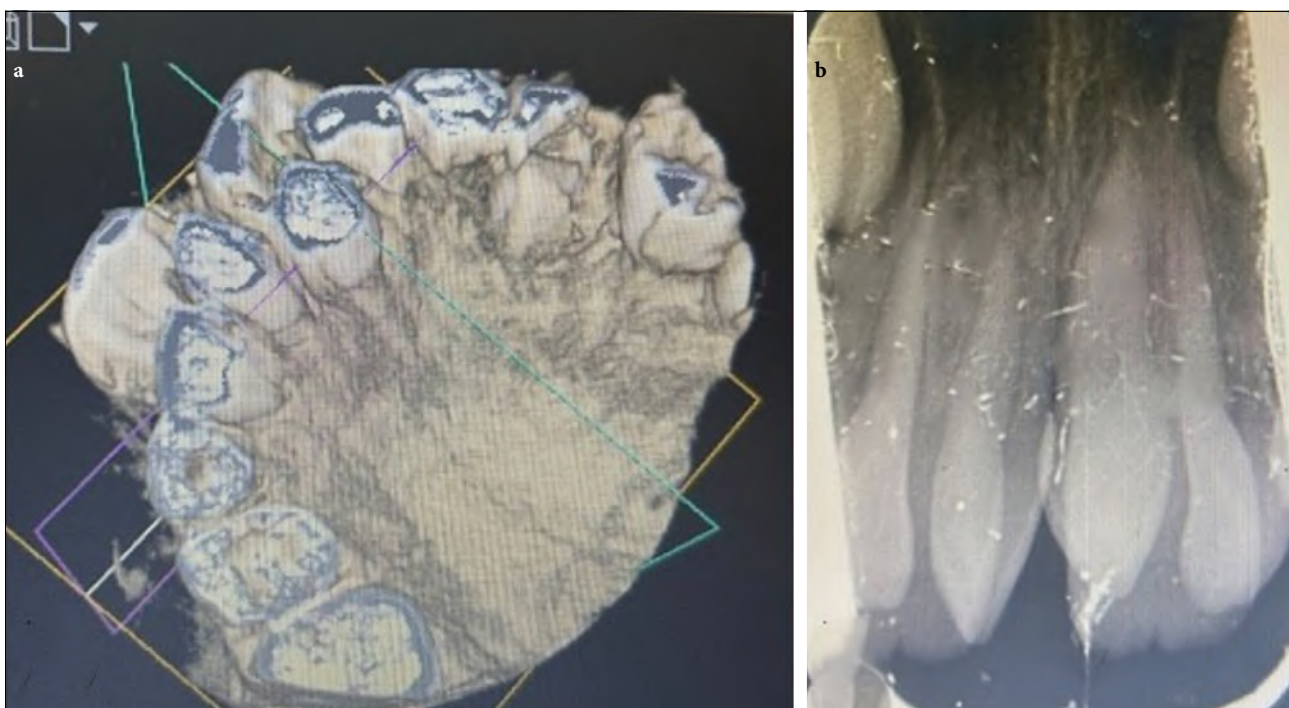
(a) CBCT showing two mesiodentes on palatal aspect. (b) IOPA reveals two mesiodentes with complete root formation
